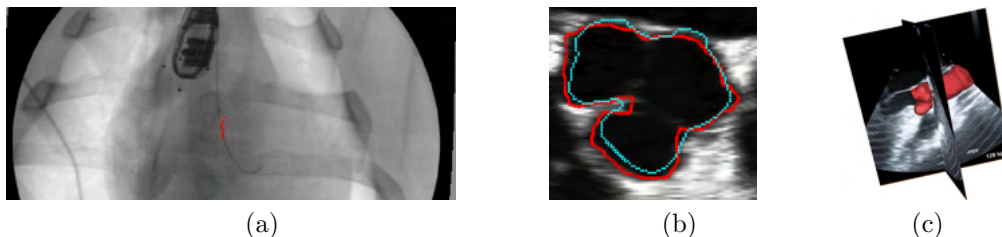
(a) Wire target points from TEE reprojected onto fluoroscopy (b) Aortic root segmentation: red - gold standard, cyan - algorithm (c) Registration of TEE to CT
